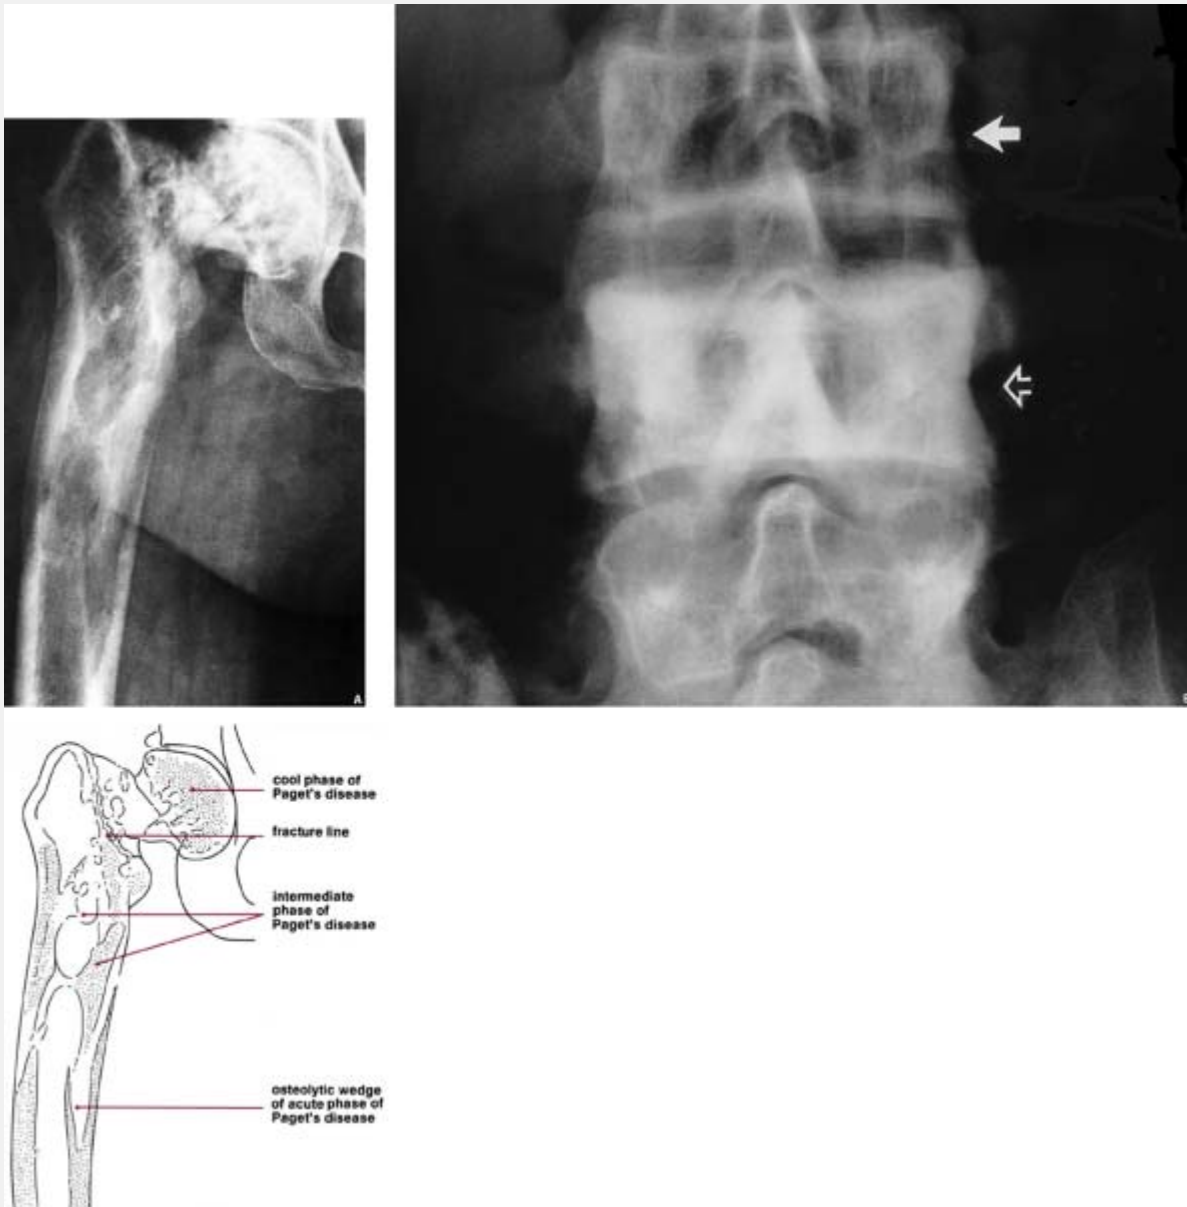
Cool phase of Paget disease. (A) Lateral radiograph
